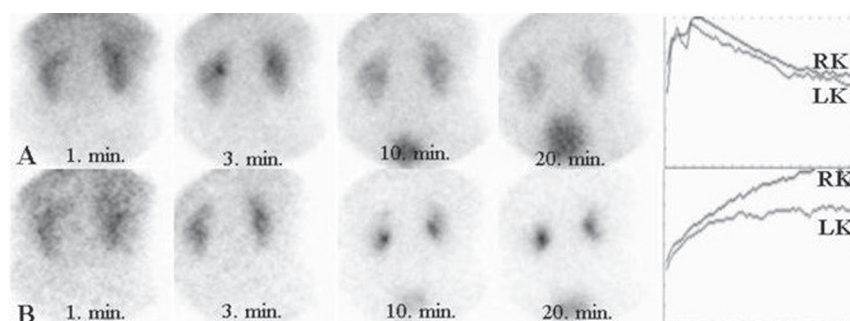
Child with transient hydronephrosis and low grade obstruction (A); False negative diuresis renal scintigraphy "F-0" result in the sitting position, and true positive finding of obstruction in the supine position in the same child (B).
